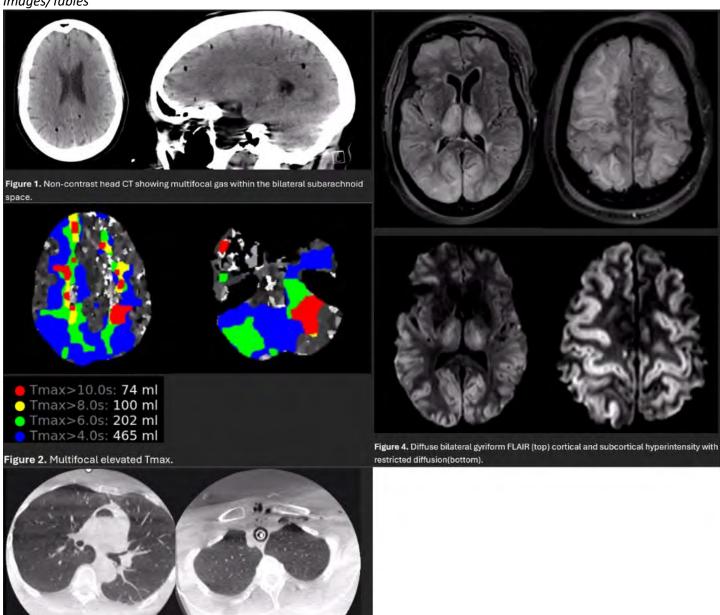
Intraoperative cone beam CT demonstrates extensive gas within the aorta(left) nd subcutaneous and venous gas(right)
